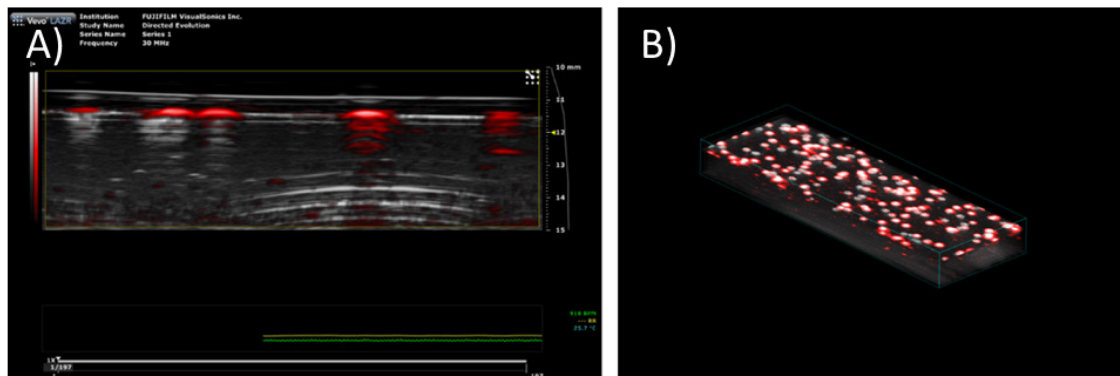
Array-based screening of *E. coli* colonies. (A) Interlaced ultrasound (gray colormap) and photoacoustic (red colormap) signals of a single slice taken with a 30 MHz array transducer. (B) A 3D reconstruction of a strip along the *E. coli* plate.
